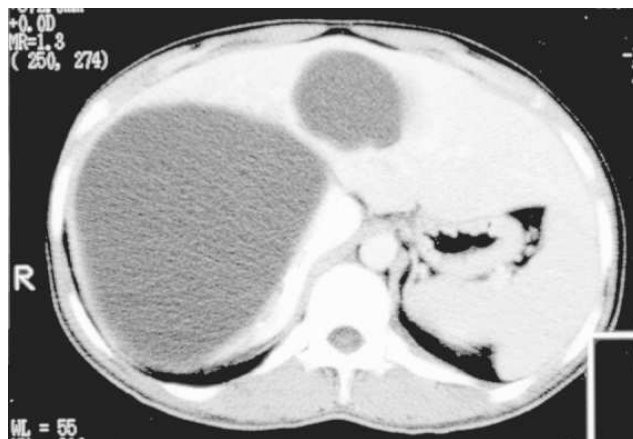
CT examination shows two hypodense cystic liver lesions. Well defined fluid collections, consistent with cyst hydatid.
